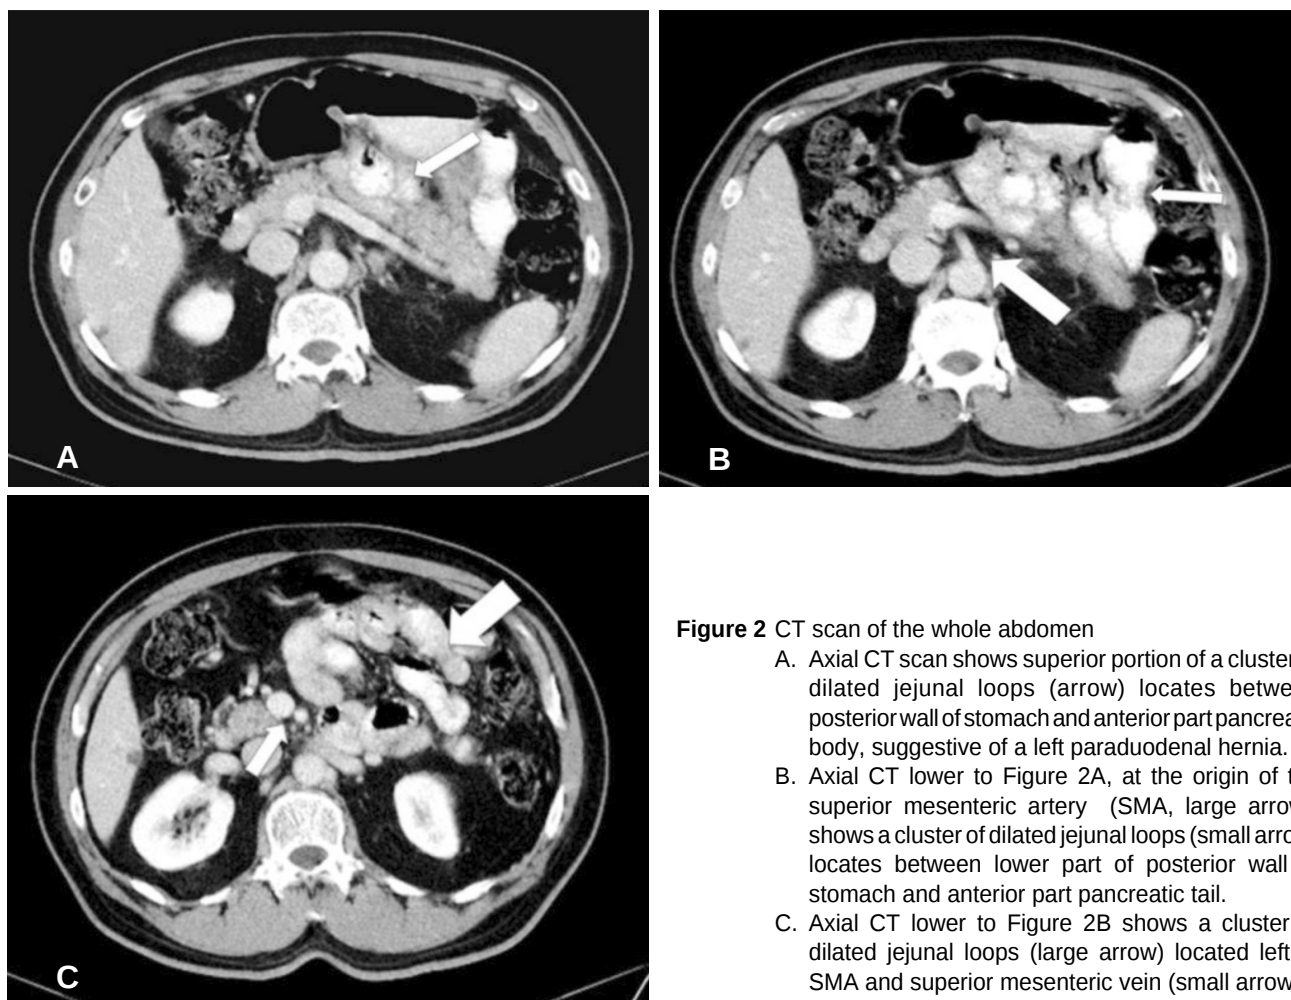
CT scan of the whole abdomen
